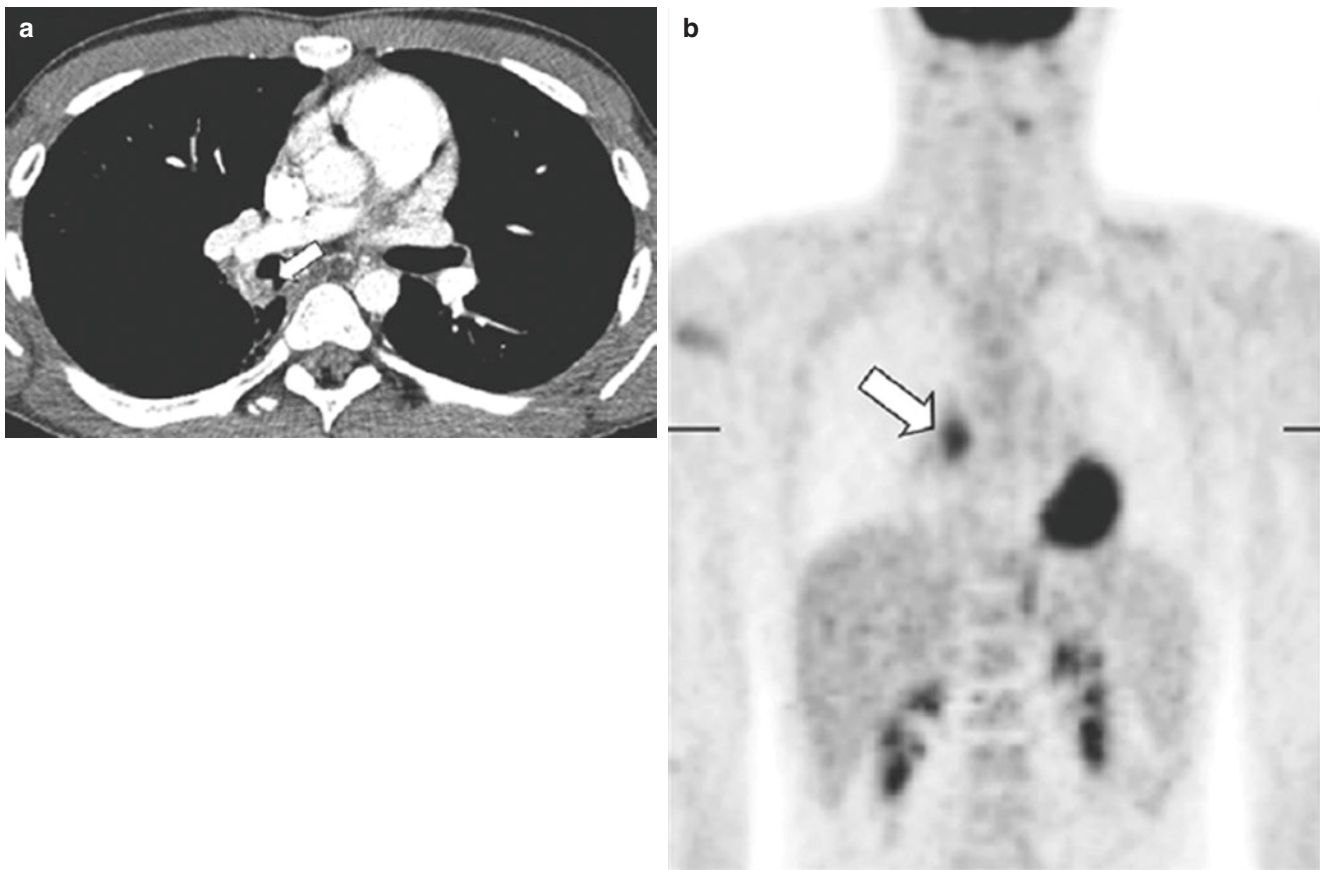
A 15-year-old boy who presented with cough and one episode of hemoptysis. (a) Enhanced axial CT image demonstrates a heterogeneously enhancing endoluminal mass (*arrow*) in the proximal right lower lobe bronchus. (b) Coronal PET image shows an abnormal
